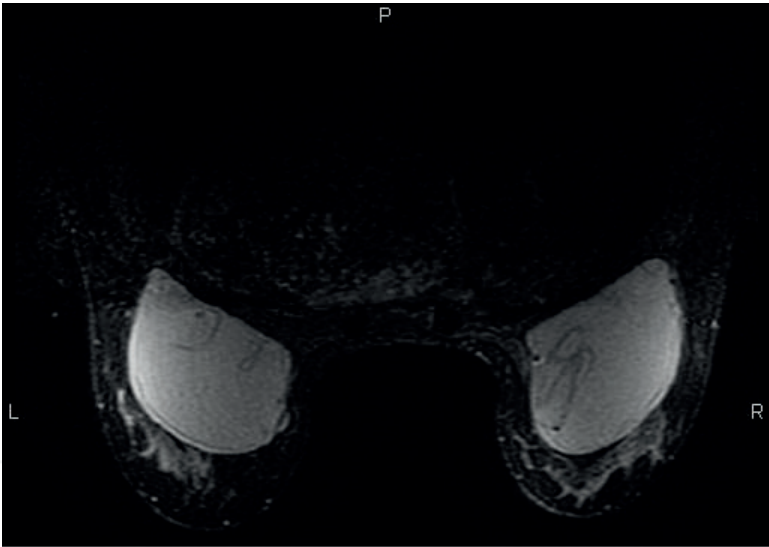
Axial T2W MRI demonstrates bilateral intracapsular silicone implant ruptures.
